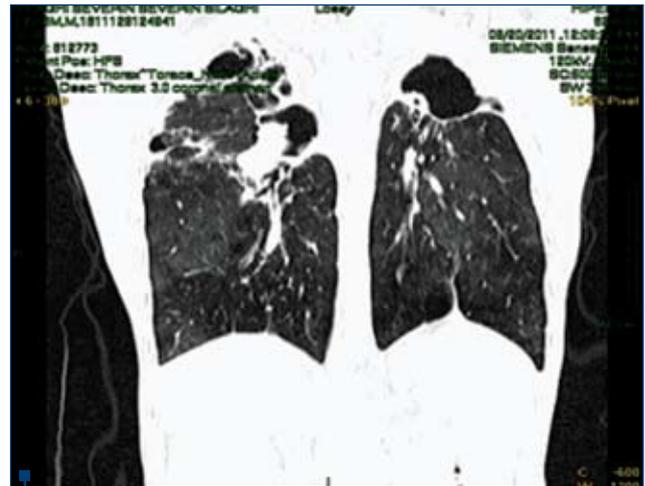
Thoracic CT scan: right - apical pulmonary retractile fibrosis including aeric cavities, some with tissue solid content (suggestive of aspergillosis). Left: apical retractile pulmonary fibrosis including several cavities (one 7 cm large), upper mediastinum shifted to left, important distortions of the mediastinum
